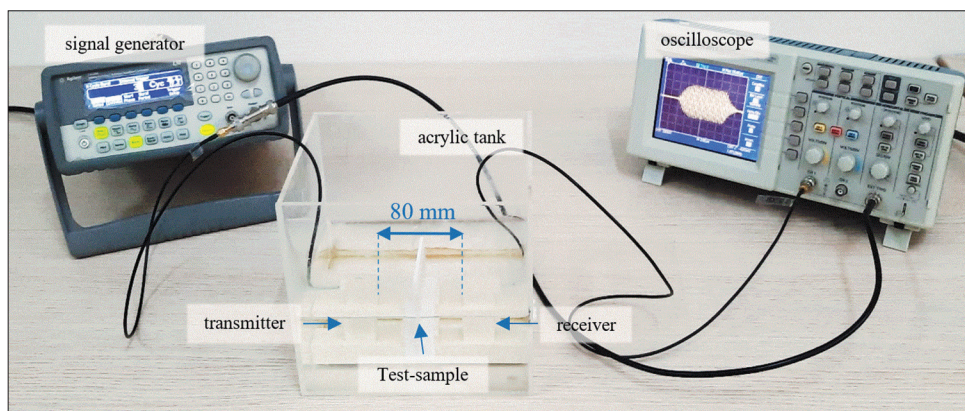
Photo of the experimental setup used to estimate the ultrasonic attenuation by the transmission-through method with indicated components
